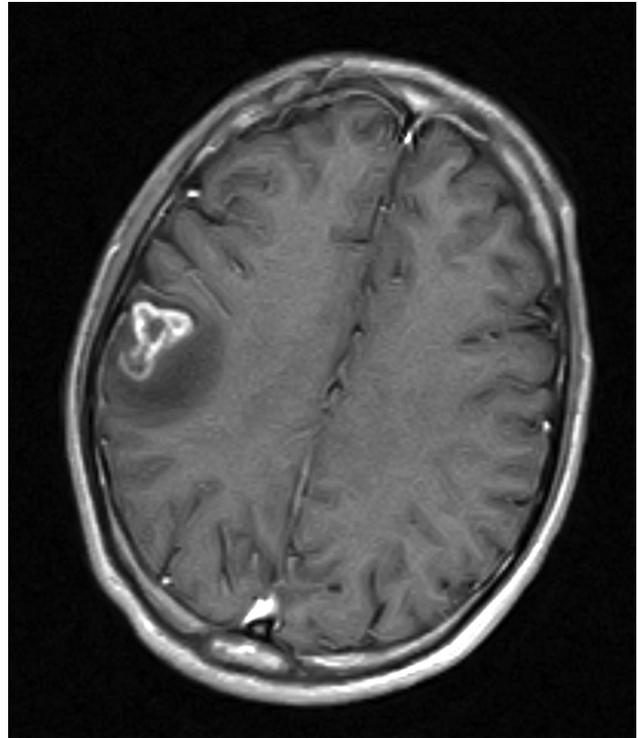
CT of the head shows a large cortical lesion with surrounding edema.
